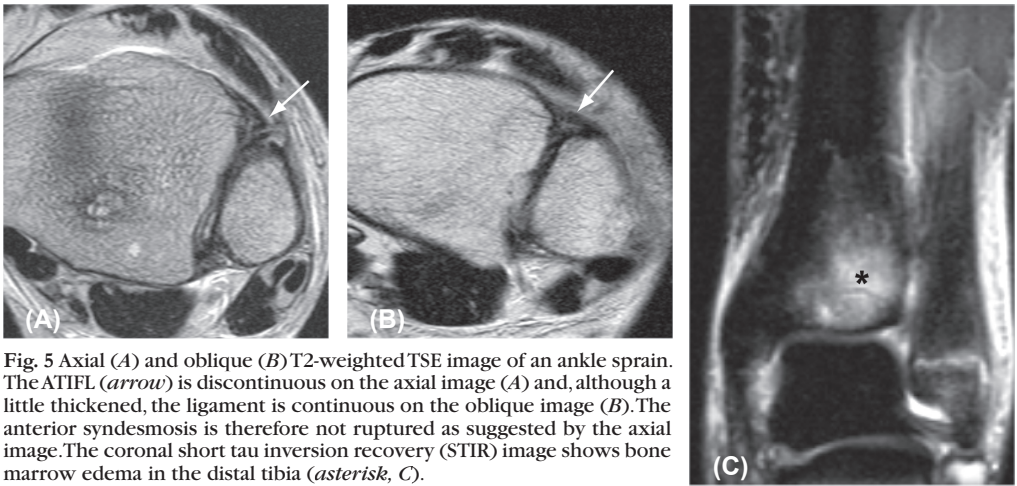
Axial (A) and oblique (B) T2-weighted TSE image of an ankle sprain. The ATIFL (arrow) is discontinuous on the axial image (A) and, although a little thickened, the ligament is continuous on the oblique image (B). The anterior syndesmosis is therefore not ruptured as suggested by the axial image. The coronal short tau inversion recovery (STIR) image shows bone marrow edema in the distal tibia (asterisk, C).
